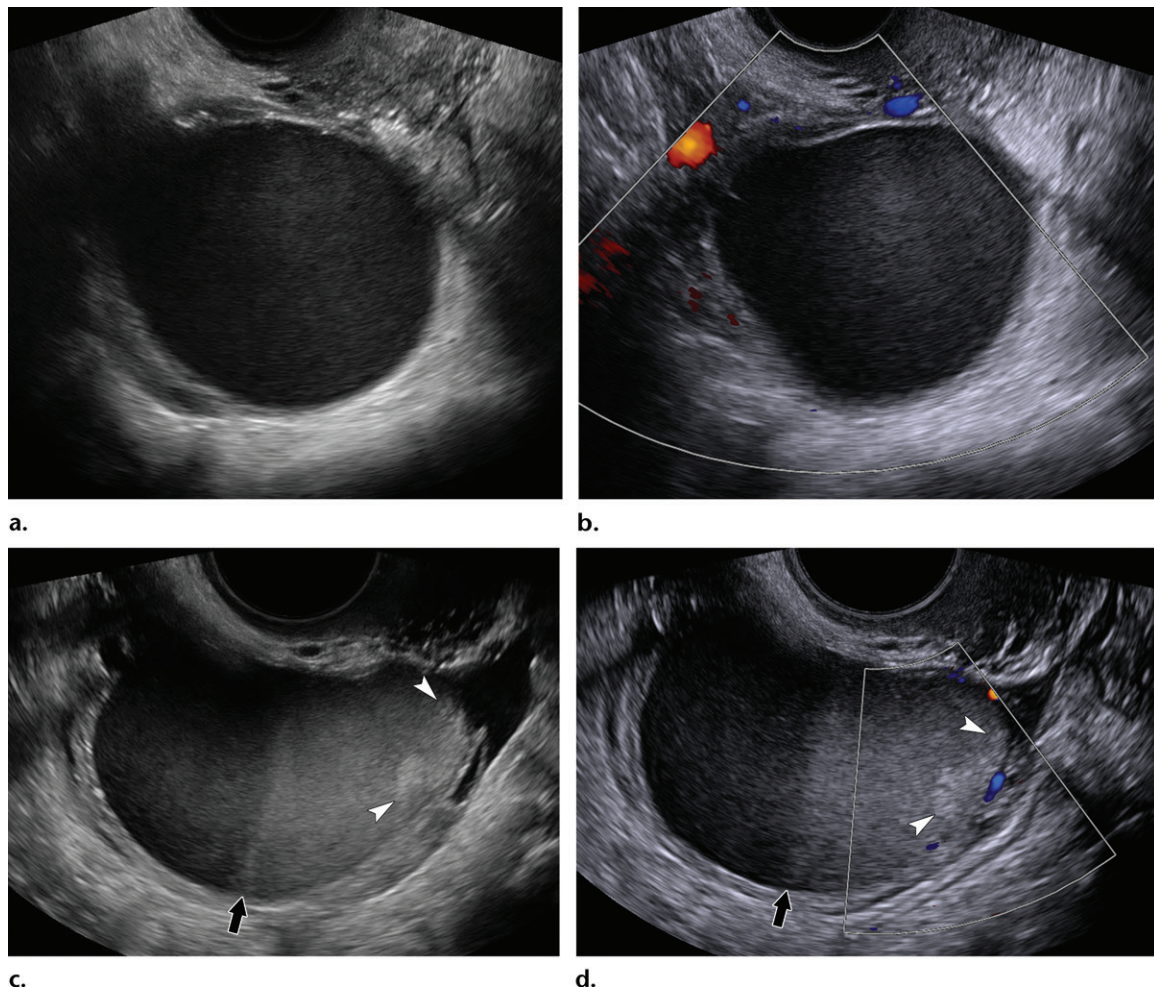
Typical and atypical ovarian endometriomas in two patients. (a, b) Transverse gray-scale (a) and color Doppler (b) TVS images in a 25-year-old woman with pelvic pain and a history of prior left oophorectomy performed secondary to endometriosis show the classic appearance of an ovarian endometrioma: a unilocular cyst containing homogeneous low-level echoes and no internal vascularity at color Doppler US. (c, d) Sagittal gray-scale (c) and color Doppler (d) TVS images in a 28-year-old woman with long-standing right lower quadrant pain and a laparoscopically confirmed endometrioma show a fluid-fluid level (arrow), with dependent hyperechoic material and an avascular nodule (arrowheads) within the endometrioma.
